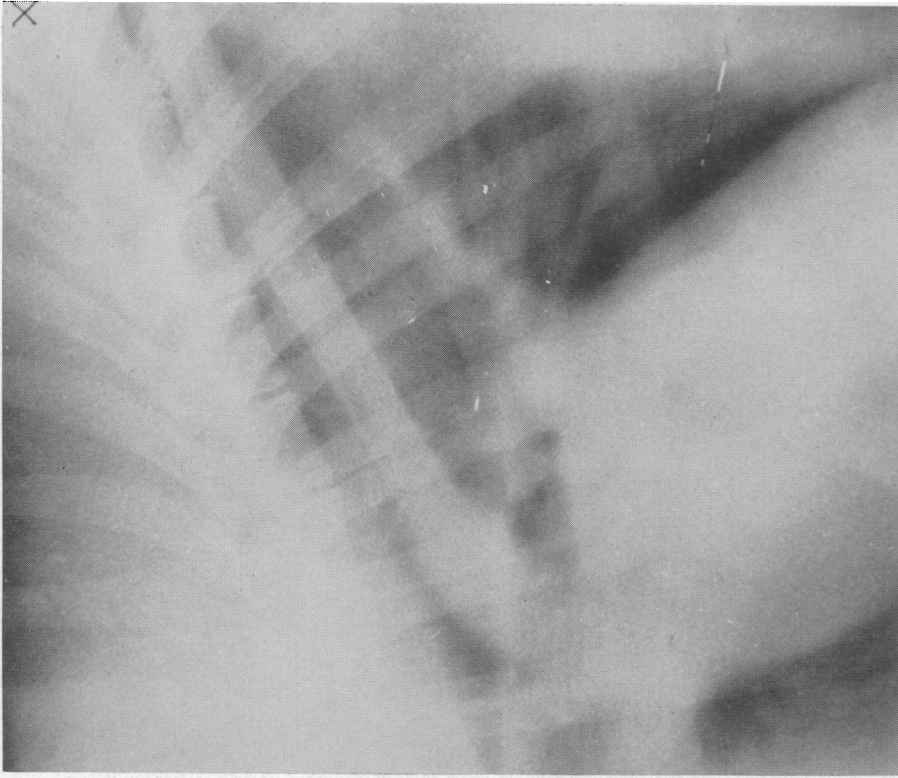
(Left) Thoracic roentgenogram of a 5.0-cm-long magnesium tube in the descending thoracic aorta. (Right) Aortogram using 75% Hypaque showing intraluminal patency of the tube seven months after implantation.
